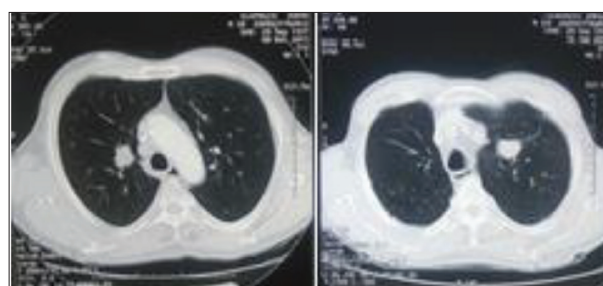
Multi-slice computed tomography findings of pathological masses in the lungs
